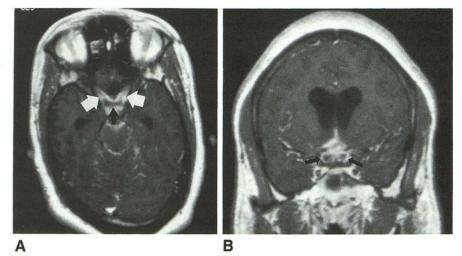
Advanced optic atrophy caused by long-standing neurosarcoidosis (case 14). Coronal enhanced (A) and sagittal T1-weighted (450/20) (B) images show severe thinning of optic nerves, chiasm, and optic tracts (*arrows*). Also note empty sella.
